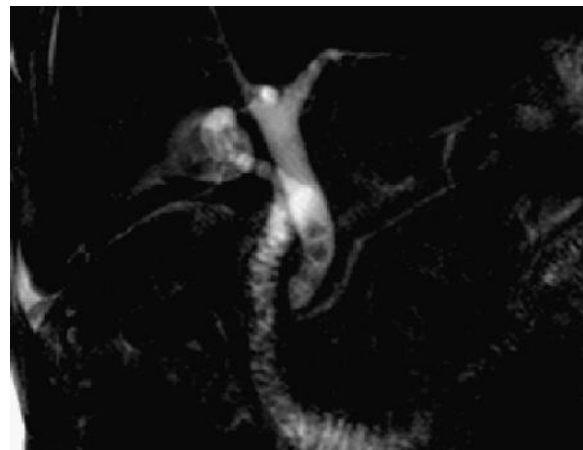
Magnetic resonance cholangiopancreatography. Several stones are visualized within the common bile duct, appearing as hypointense filling defects on T2-weighted images. (Courtesy Christopher S. Huang.)
